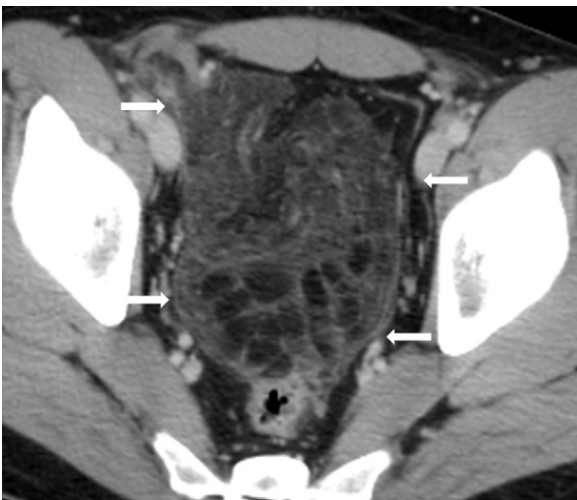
CT shows a large fat density mass in the middle lower abdomen (arrows).
